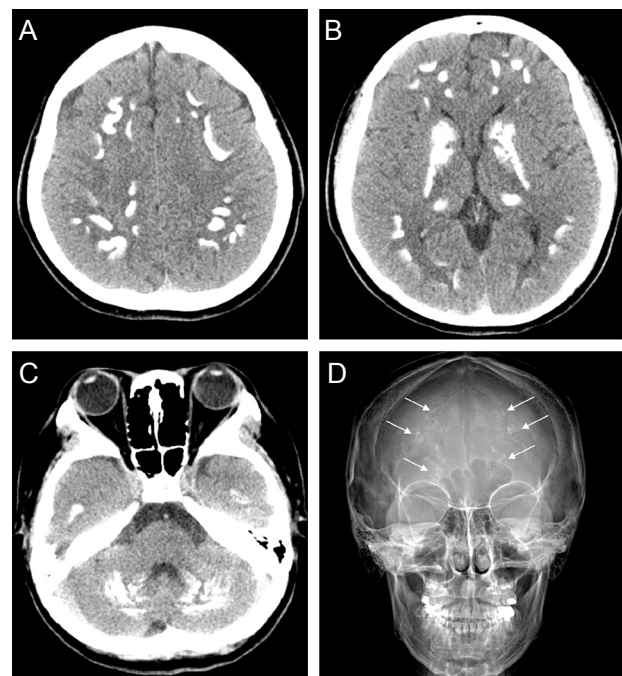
Brain CT demonstrates extensive symmetric calcifications in corticomedullary junctions (A), basal ganglia and thalami (B), and cerebellar hemispheres (C). Calcifications of the brain are also seen in a cranial radiograph (D). Arrows indicate calcifications.
